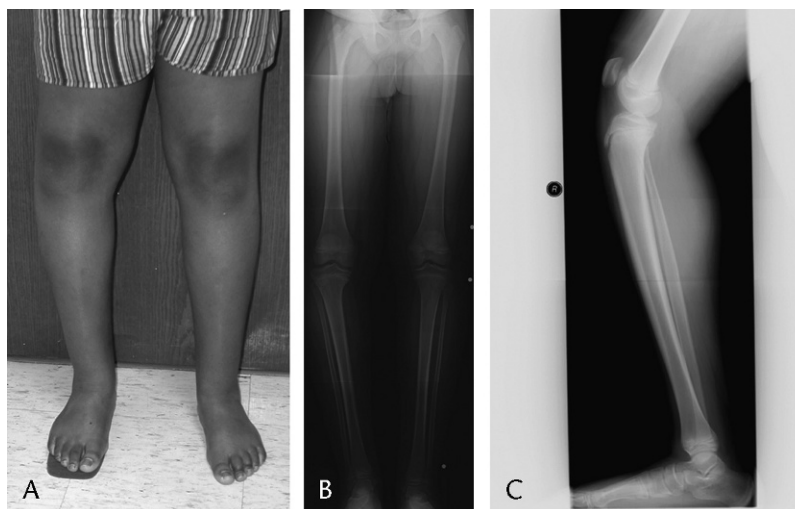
A, Clinical appearance of a 12.6-year-old boy with unilateral late-onset Blount disease. Note the lift under the right foot to compensate for shortening of the affected limb. B, Standing AP radiograph of the same patient. He had 60 mm of medial MAD on the right side. His LDFA-m measured 92 degrees on the right side and 86 degrees on the left side. Medial proximal tibial angle was 78 degrees on the right side and 88 degrees on the left side. C, Lateral view of the right tibia demonstrating 19 degrees of procurvatum deformity with a PPTA of 61 degrees.
